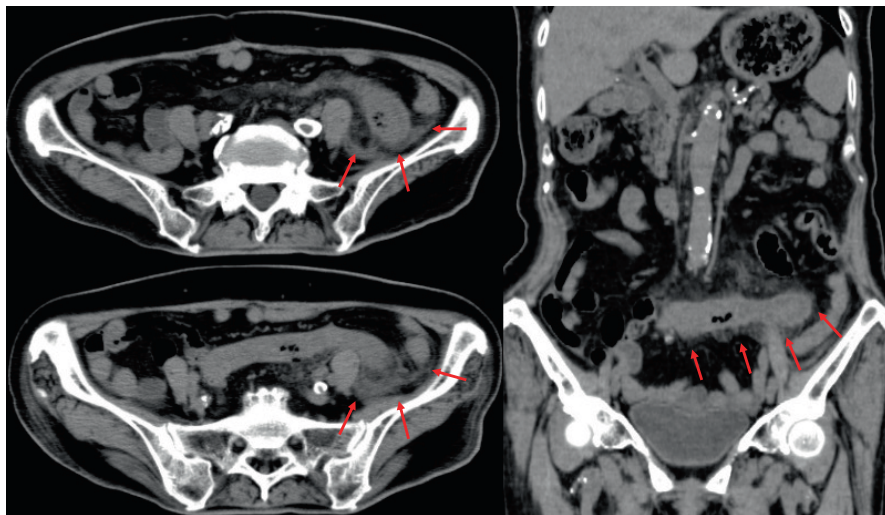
Computed tomography of her abdomen showed edematous thickening of the wall of the descending colon.
